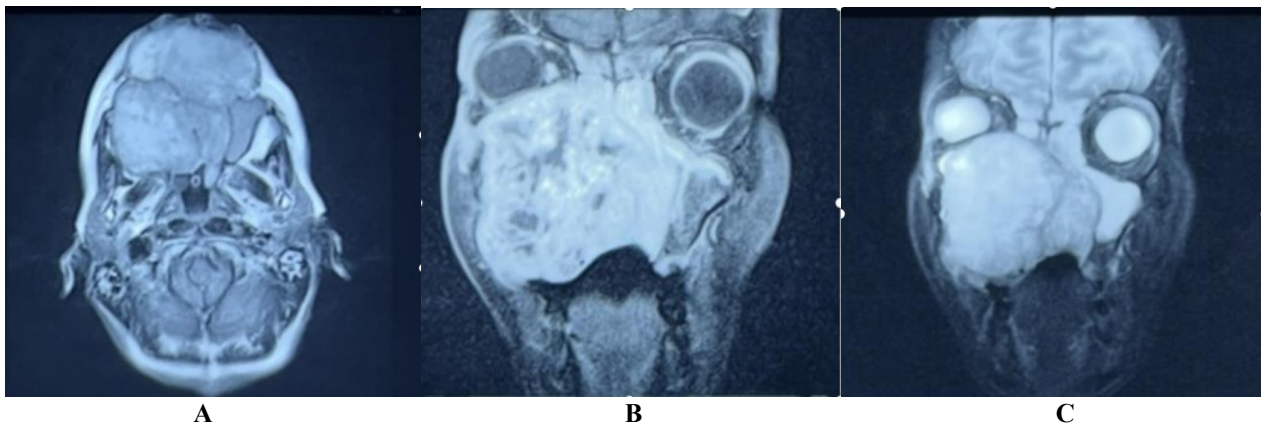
Magnetic resonance images. (A) Axial T1-weighted image demonstrating a soft tissue mass of intermediate signal intensity with a few punctiform high signals. (B) Post-contrast coronal T1 image showing enhancement of the mass, delimiting necrotic fluid areas. (C) Coronal T2-weighted image; the mass exhibits high signal intensity
